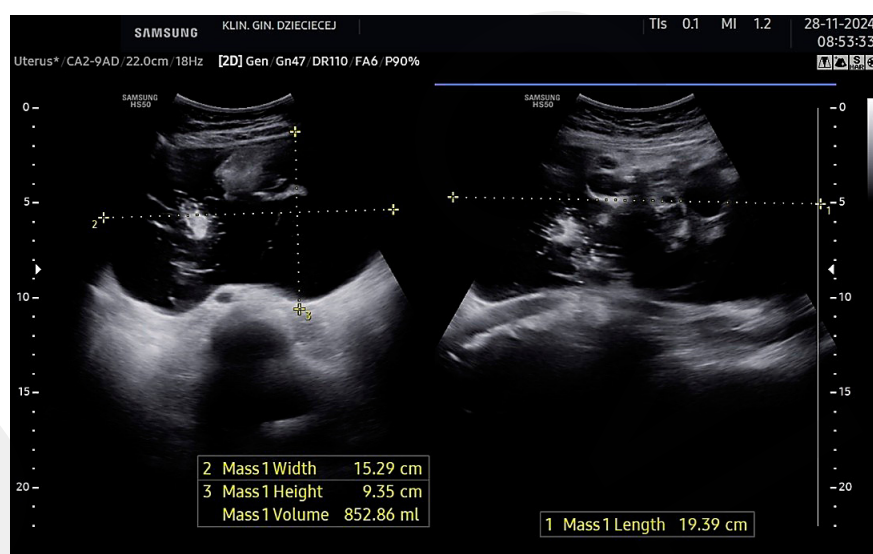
Ultrasonography (Case 2)
